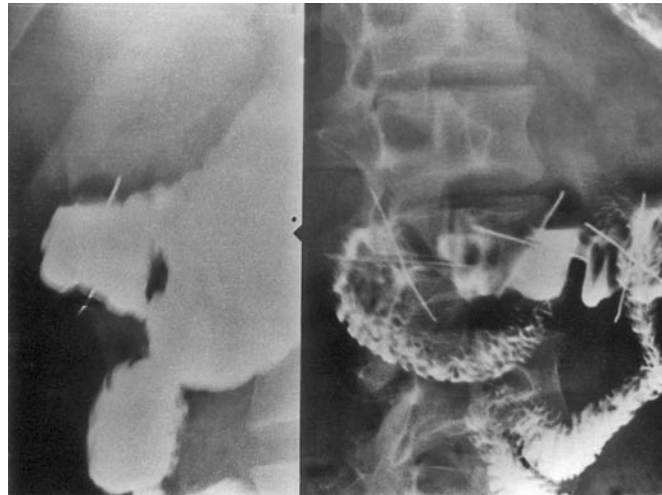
Abdominal meglumine amiodotriozate contrast radiographs. The view on the right shows one prepyloric "cross" and two crosses in the first part of the duodenum. The oblique view (left) demonstrates branches of a cross protruding beyond the confines of the duodenal lumen, indicating perforation.
